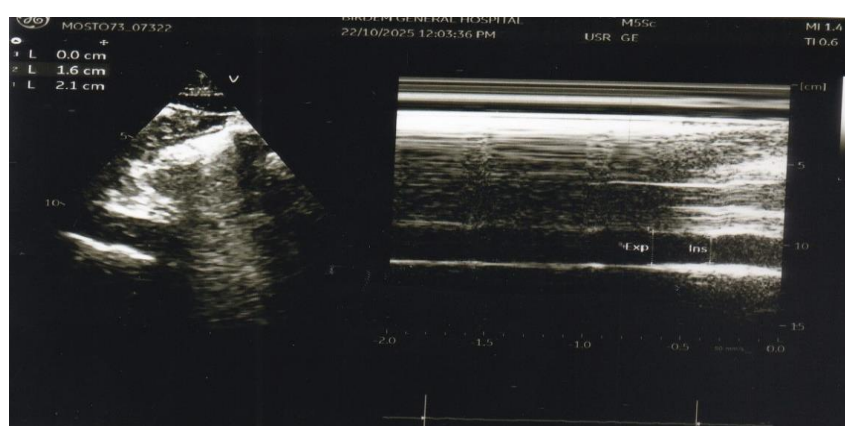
M-Mode Echocardiography image showing changes in IVC diameter during expiration and inspiration
